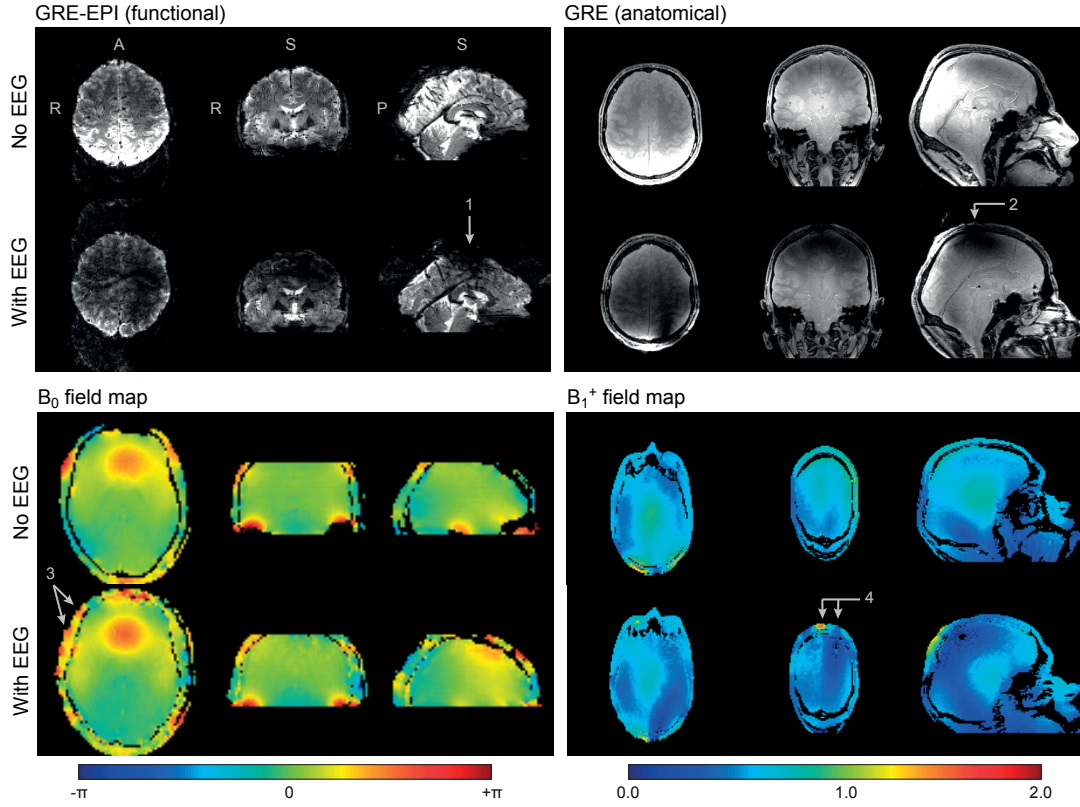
MRI data quality in a human subject scanned without (1st and 3rd rows) and with the EEG cap (2nd and 4th rows). The slices presented contain the most relevant differences between the two conditions. Top-left: GE-EPI image acquired with similar parameters to the functional runs (although with larger coverage). Top-right: GRE-based anatomical image. Arrows 1 and 2 indicate accentuated local signal drops. In both functional and anatomical images, the intensity scale is kept fixed between no-EEG and with-EEG conditions. Bottom-left: \vec{B}_0 field distribution, expressed as the phase shift relative to the nominal precession; local phase shifts appearing along the skin are indicated by arrow 3. Bottom-right: \vec{B}_1^+ field distribution, expressed as a fraction of the nominal flip angle; accentuated local field variations are indicated by arrow 4. Both \vec{B}_0 and \vec{B}_1^+ field maps here shown were masked to remove background regions in which there was no MR signal.
